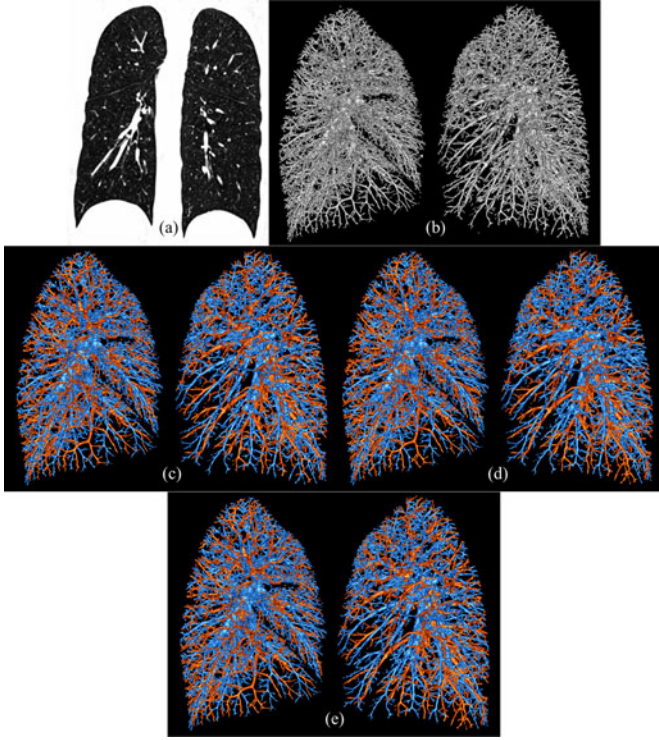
Results of A/V separation on pulmonary CT data. (a) Coronal image slice. (b) 3-D rendering of the vasculature. (c), (d), and (e) Color-coded rendering of A/V separations using seeds from three independent experts.
